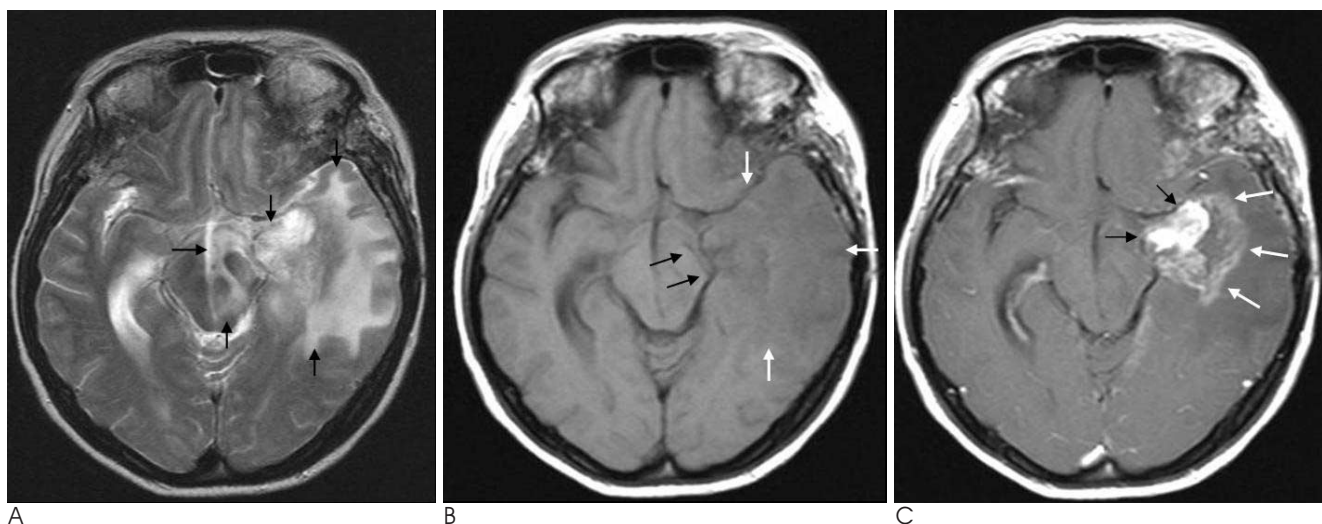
An axial T2-weighted image (A) demonstrates diffuse high signal intensity in the left temporal lobe and left sided midbrain with gyral swelling (black arrows). This lesion shows diffuse low signal intensities in the left temporal lobe (white arrows) with mild compression of the left sided midbrain due to the mass effect (black arrows) on the axial T1-weighted image (B). C. A Gd-enhanced axial T1-weighted image shows a strongly enhanced, irregular mass at the left medial temporal lobe representing a recurrent meningioma (black arrows) with a slightly enhancing mass in the temporal lobe adjacent to the recurrent meningioma, probably due to radiation necrosis (white arrows) and extensive edema in the left temporal lobe.
